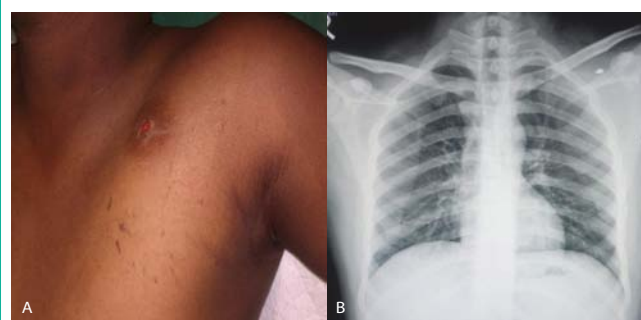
A) Entry wound in supraclavicular region due to stone chip. B) Chest X-ray showing radio opaque stone chip below left clavicle.
